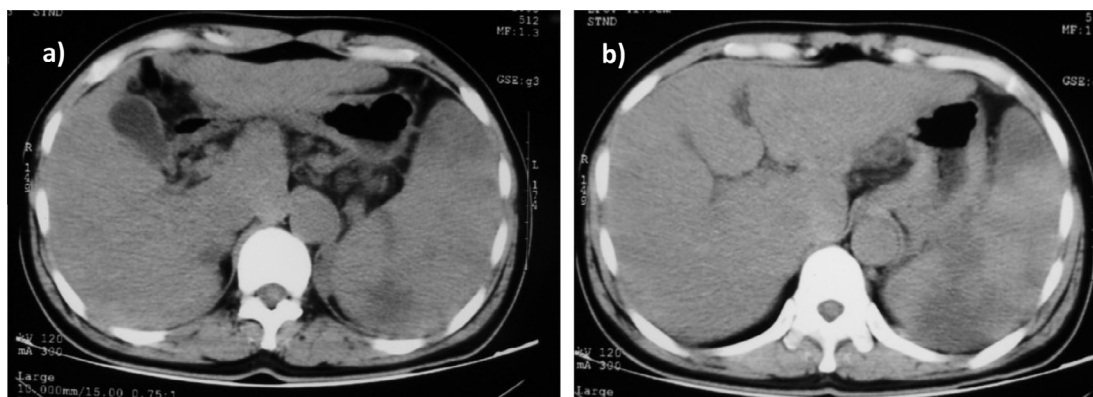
Unenhanced CT scan for the upper abdomen showing splenic infarctions: (a) 1 week after the 1st session showing hypodense splenic focal defects representing infarctions, (b) 1 week after the 2nd session showing further extensive splenic infarctions with reduced size of the spleen notably its anterior pole from previous infarction.
